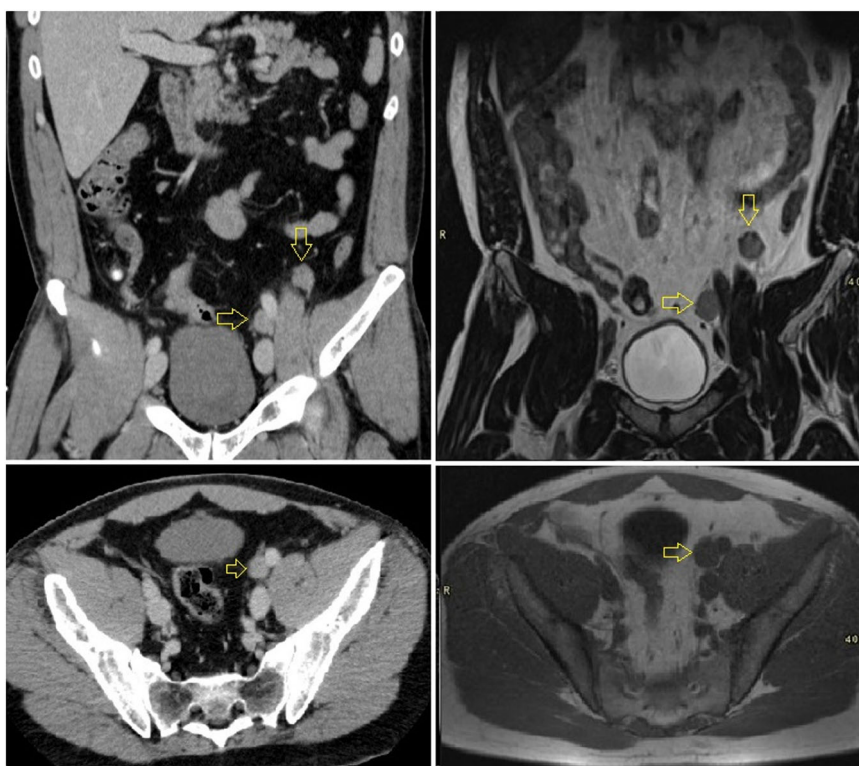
For assessment of recurrence in retroperitoneal LN, contrast-enhanced CT (left images, coronal and axial) and MRI (right images, coronal T2-Weighted and axial T1-weighted) provide similar morphological assessment of LNs, based on size criteria. Enlarged LNs (yellow arrows) can readily be detected as suspicious on both imaging modalities
